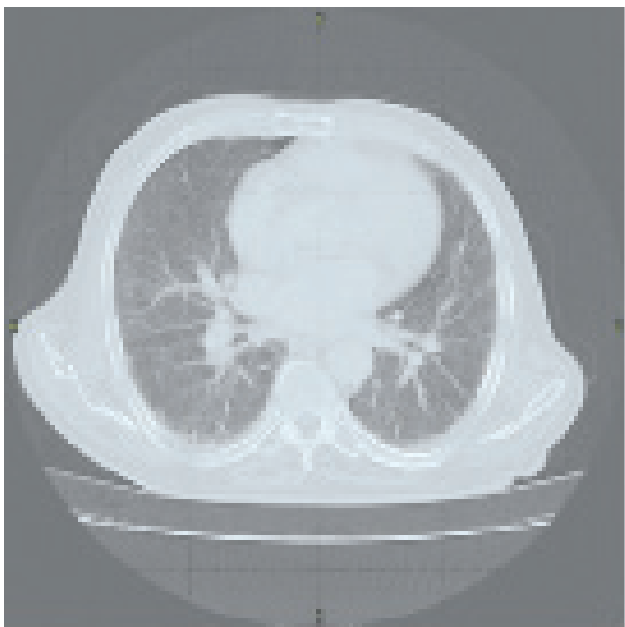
Chest CT depicting bilaterally increased subpleural interstitial pattern accompanied by bilateral pleural reactions
